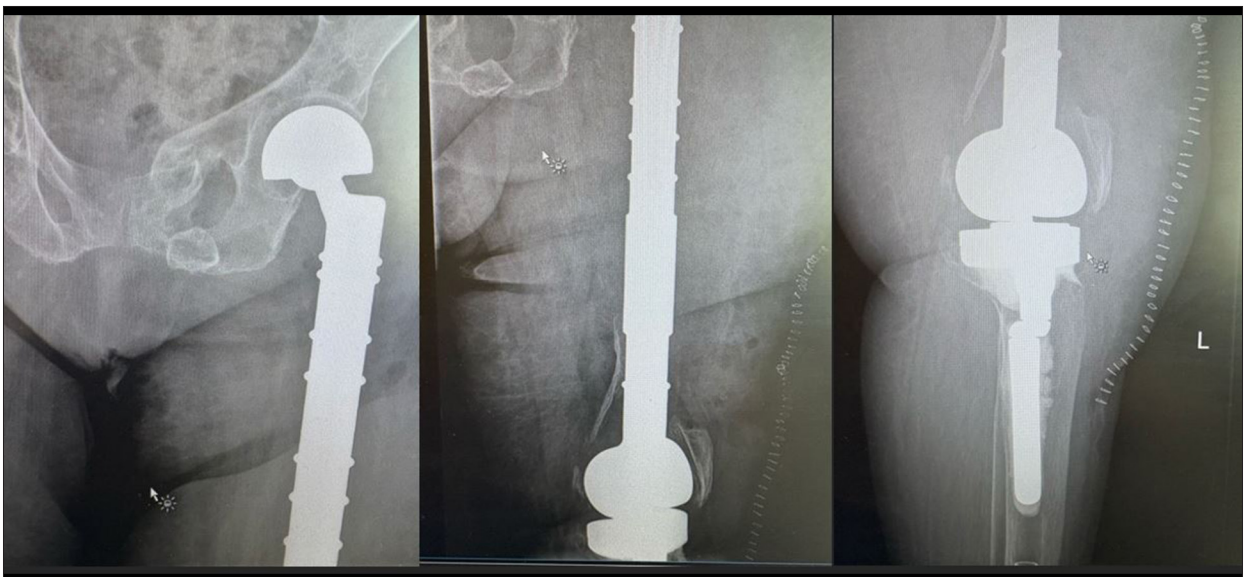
Postoperative radiographs of the left lower extremity demonstrating the implanted total femoral prosthesis (4 months after presentation).
